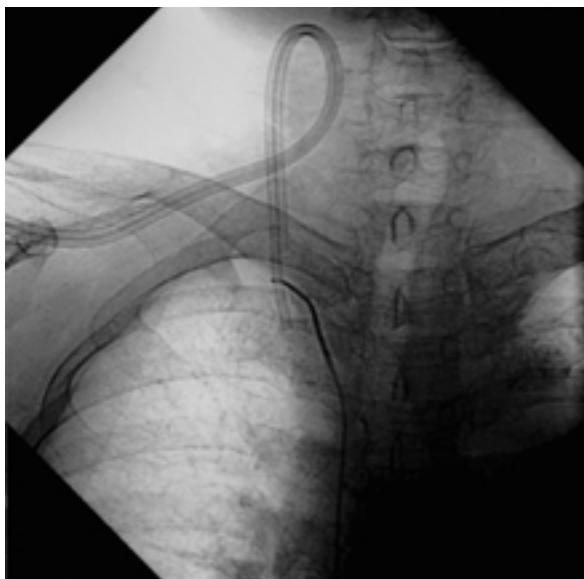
Radiograph shows that the tip of the central venous catheter is caught by a snare loop inserted via right common femoral vein.
